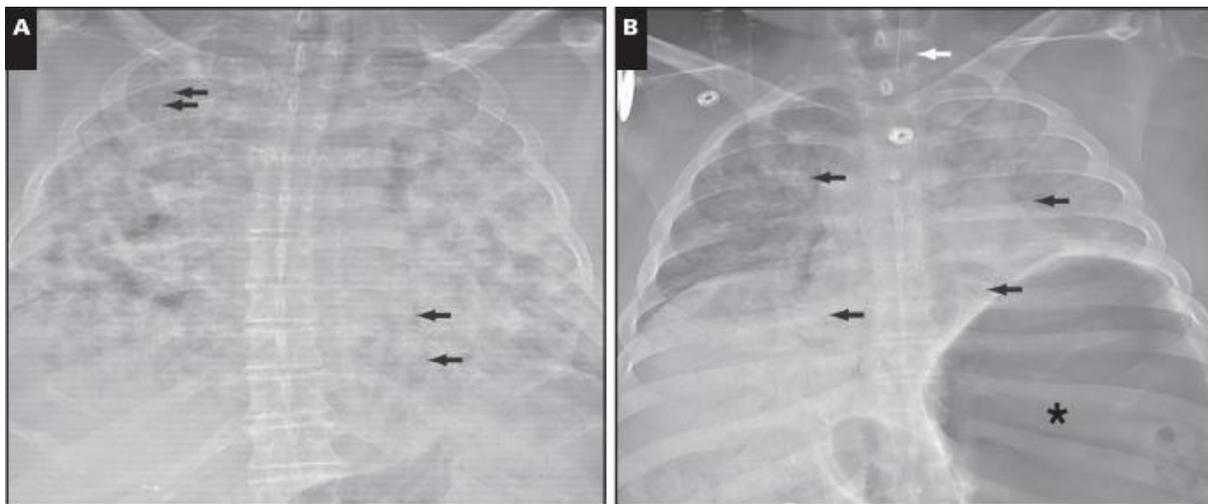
Postmortem anterior-posterior chest radiographs. A, Case 1. Diffuse, dense bilateral airspace consolidations (complete "whiteout"). Multiple air bronchograms are present (arrows). The autopsy in this case showed diffuse alveolar damage. B, Case 2. Diffuse airspace opacities in both lungs, less consolidative in comparison to part A. Multiple bilateral air bronchograms are highlighted (arrows). The left lung is asymmetrically slightly more consolidated compared to the right. An endotracheal tube is shown with its tip above the level of the clavicular heads in the cervical trachea (white arrow). There is marked
